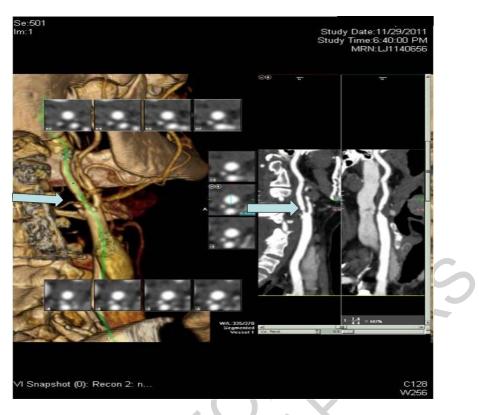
Computed Tomography Angiogram showing severe stenosis at the internal carotid artery (arrows)
